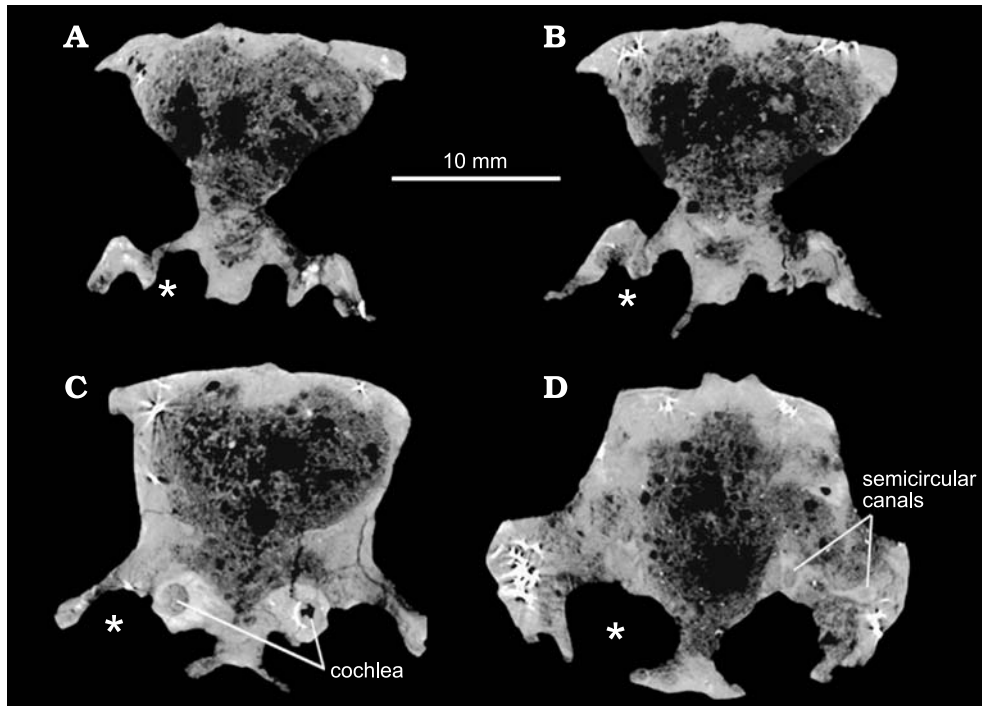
CT cross sections through the mesocranium and ear region of a *Tombaatar* sp. skull from Ukhaa Tolgod, Mongolia, PSS-MAE 630. The * represents the middle ear cavity and its connection to the choanal passage.
